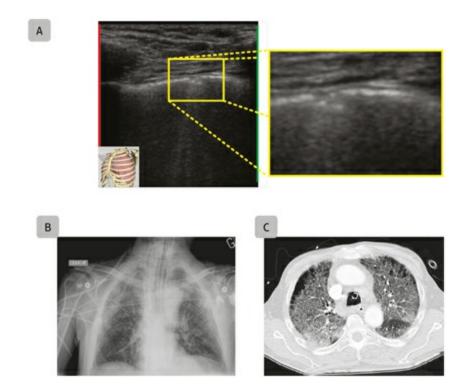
Pulmonary fibrosis. (A) Lung ultrasound (zone 7) in a patient with pulmonary fibrosis on the left compared with (B) a patient with pulmonary edema on the right side. Both pathologies exhibit multiple B-lines, but pulmonary fibrosis also has irregular pleural thickening.
